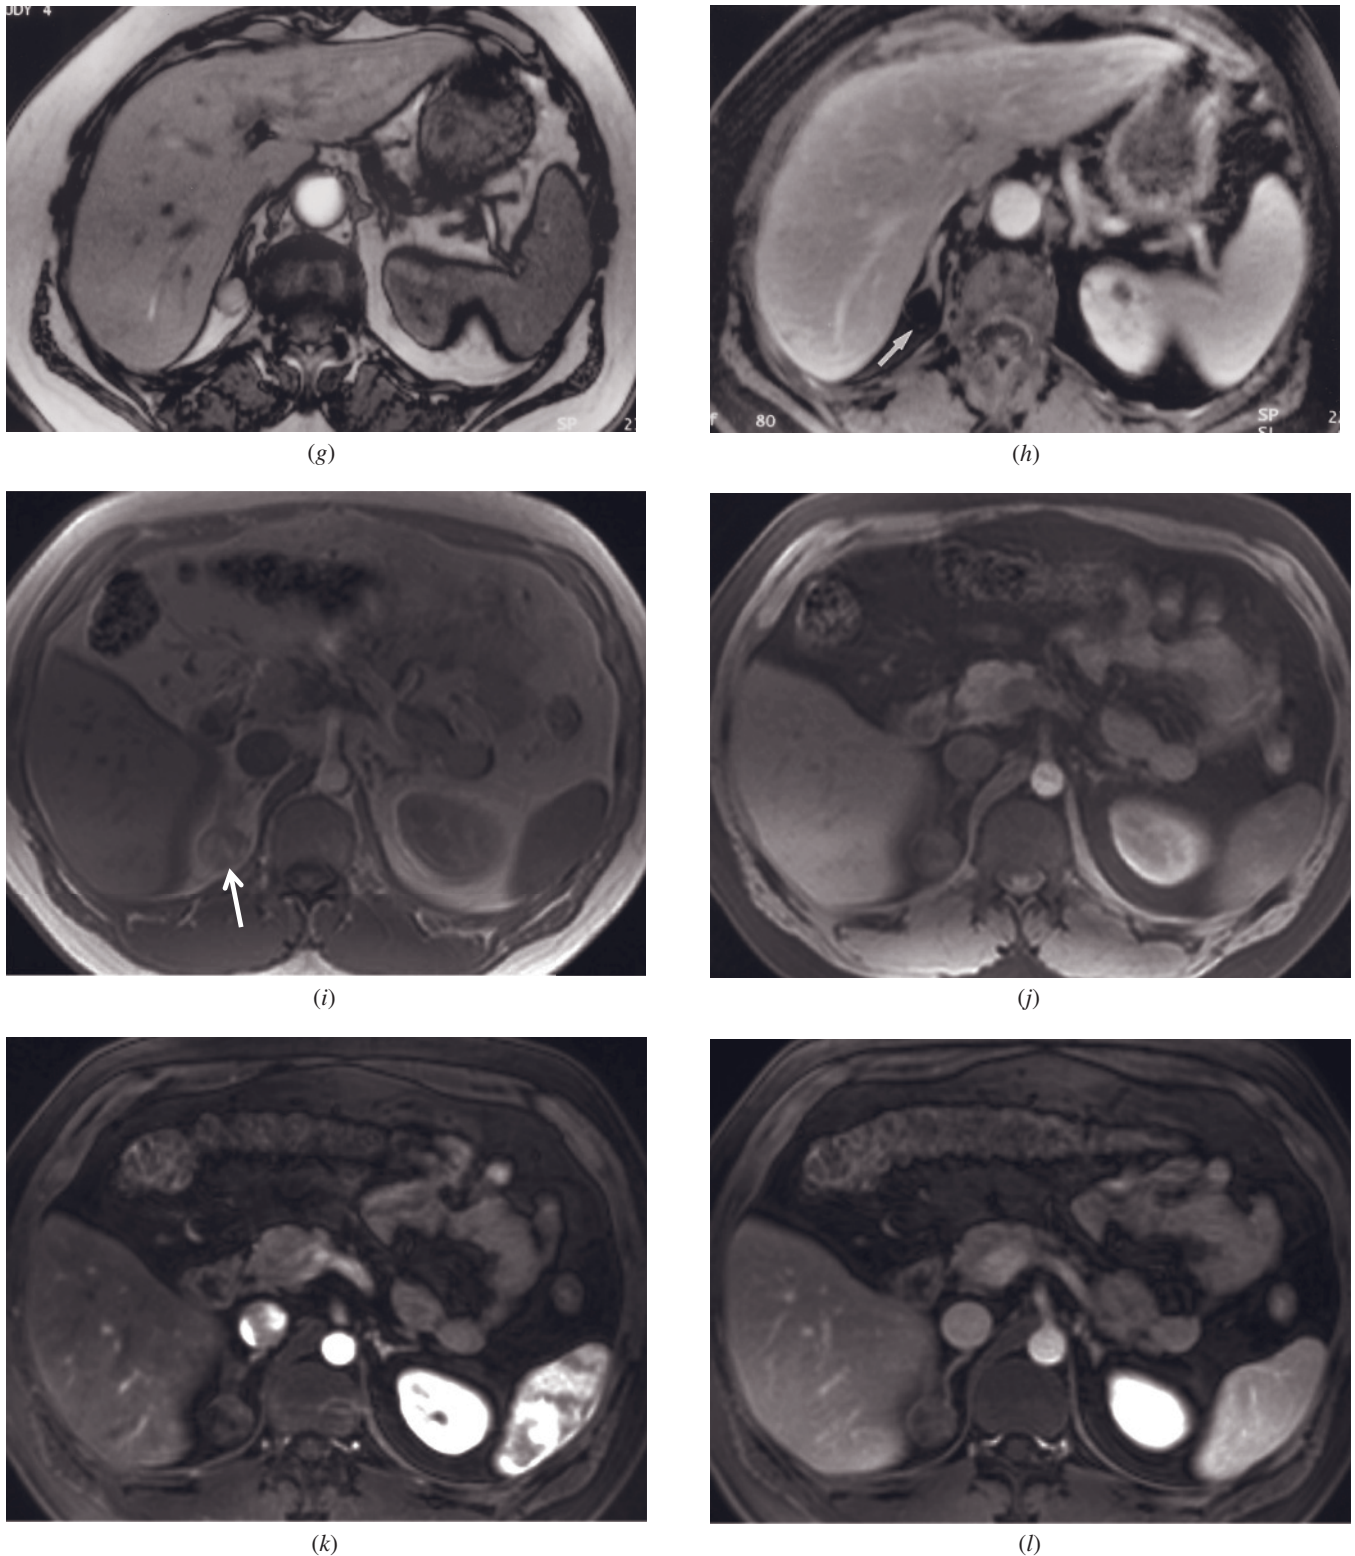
(*Continued*) signal is present on the out-of-phase image (g), reflecting the near complete absence of water protons in the mass. On the fat-suppressed image, the mass is near signal void (arrow, *h*), confirming that it is essentially all fatty in composition. T1-weighted SGE (*i*), T1-weighted fat-suppressed SGE (*j*), T1-weighted postgadolinium hepatic arterial dominant phase (*k*) and hepatic venous phase (*l*) images at 3.0T demonstrate myelolipoma of the right adrenal gland in another patient. High-signal-intensity component of the lesion seen on T1-weighted image (*i*) shows low signal on fat-suppressed images (*j-l*). These findings are consistent with the diagnosis of myelolipoma.
